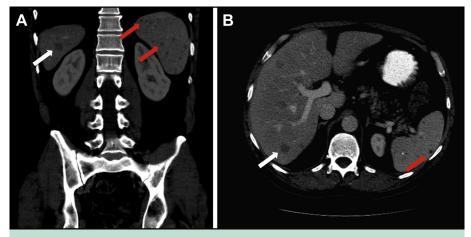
Computed tomography (CT) of the chest, abdomen, and pelvis was obtained. (A) Coronal views disclosed numerous hypodense lesions in the liver (white arrows) and spleen (red arrows). (B) Transverse views showed the same. The largest lesion measured 1.3 cm (white arrows).
